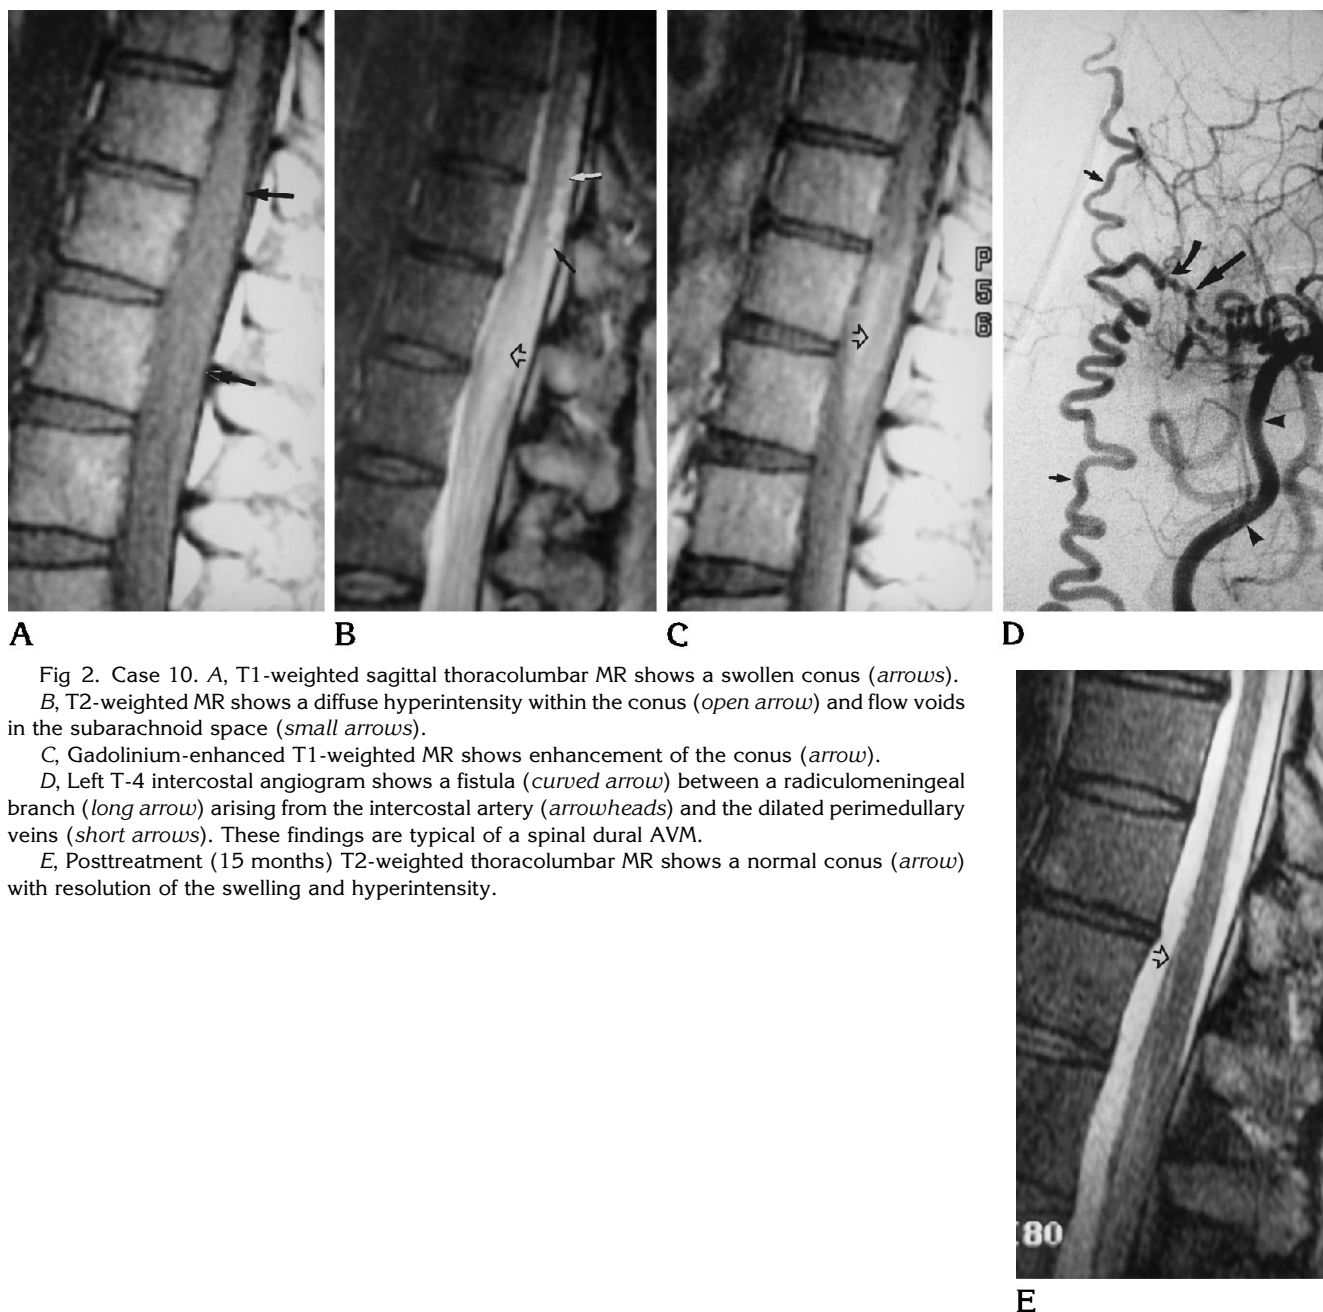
Case 10. A, T1-weighted sagittal thoracolumbar MR shows a swollen conus (arrows). B, T2-weighted MR shows a diffuse hyperintensity within the conus (open arrow) and flow voids in the subarachnoid space (small arrows). C, Gadolinium-enhanced T1-weighted MR shows enhancement of the conus (arrow). D, Left T-4 intercostal angiogram shows a fistula (curved arrow) between a radiculomeningeal branch (long arrow) arising from the intercostal artery (arrowheads) and the dilated perimedullary veins (short arrows). These findings are typical of a spinal dural AVM. E, Posttreatment (15 months) T2-weighted thoracolumbar MR shows a normal conus (arrow) with resolution of the swelling and hyperintensity.
